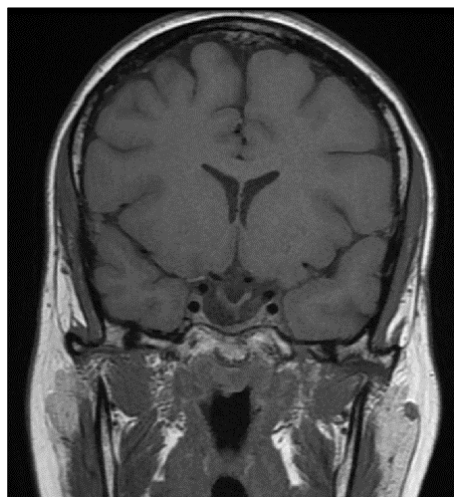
Coronal T1W image demonstrates: absence of pituitary lesion detectable by MRI without Gadolinium injection
